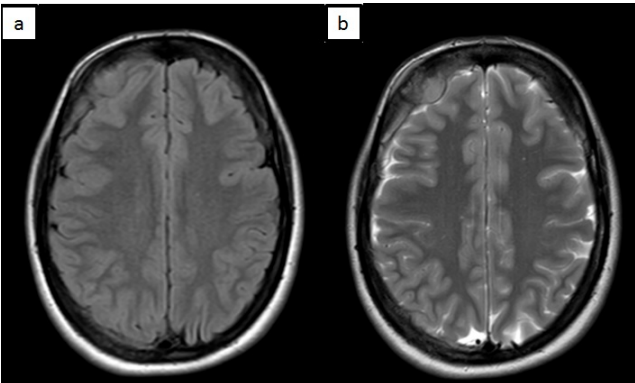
Brain MRI showing irregular dural thickening at the right frontal lobe having a band-like appearance with a nodular component associated to an overlying mild hyperostosis and a minimal overlying soft tissue thickening having an intermediate to high T2/Flair signal intensity. 2a: Flair, 2b: T2.
